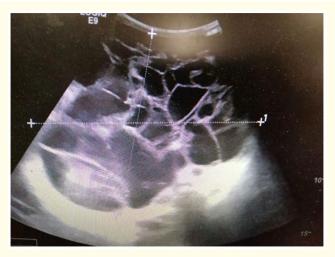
Abdominal ultrasound scan showing cysts.
